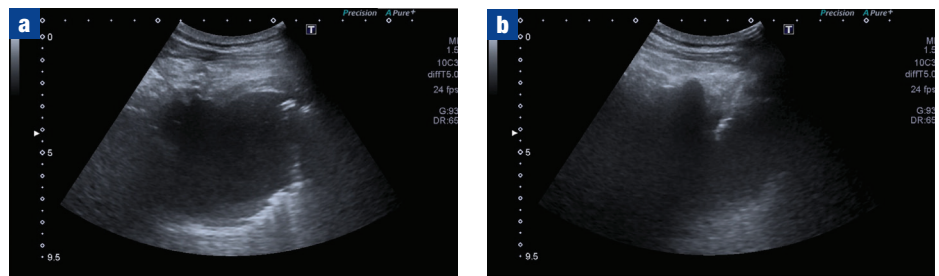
Ultrasound-guided biopsy. a. Initial ultrasound scan shows a mass abutting pleura. b. Ultrasound is used to demonstrate the co-axial needle advancing into the mass in 'real time' before samples are taken.
